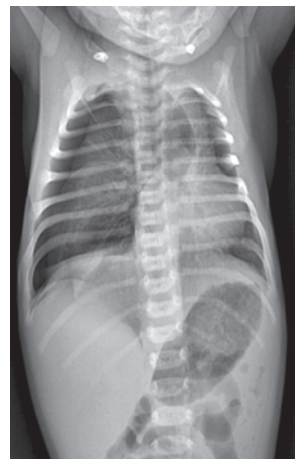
X-Ray chest: Right pneumothorax
